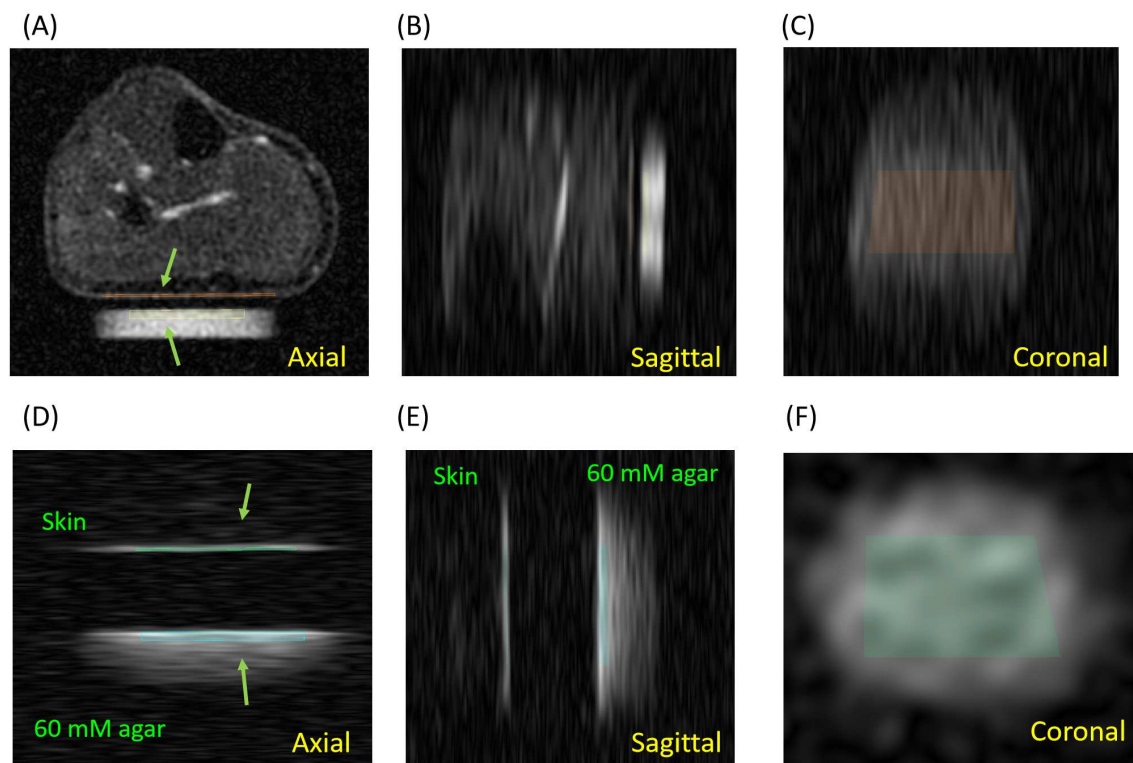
Representative ROIs for volume coil and surface coil imaging shown in the axial, sagittal and coronal planes. Arrows in (A)&(D) point to the ROIs in skin and agar respectively. (A) (B) (C): ROIs are shown in axial, sagittal and coronal sodium MRI images acquired by volume coil. Sodium signal in the skin is noticeably higher than the sodium signal in subcutaneous fat tissue. There's also a noticeable amount of signal in muscle and blood veins. (D) (E) (F): ROIs in axial, sagittal, and coronal views acquired using a surface coil. The sodium signal in the skin is sharply distinguished from adjacent air and adipose tissue. However, sodium in deeper muscle tissues is not visible due to the surface coil's sensitivity to superficial layers.
